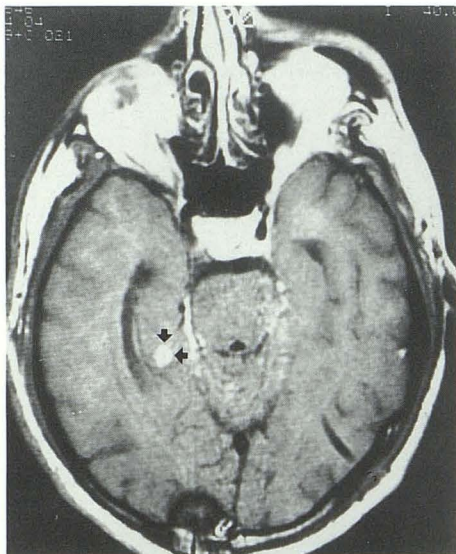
Patient 7; 37-year-old man with AIDS and coccidioidal meningitis who has had a ventriculoperitoneal shunt. Gd-DTPA-enhanced T1-weighted (800/20) axial image showing coccidioidal abscess in the mesial right temporal lobe, or possibly abnormal meningeal enhancement in the choroidal fissure (arrows).
